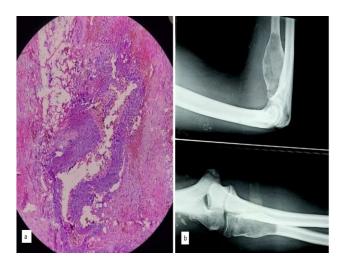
(A and B): blood-filled cystic spaces separated by septa containing woven bone, bland fibroblasts, and multinucleated osteoclastic giant cells; plain radiograph showing moderate sclerosis and thickening of cortex.
